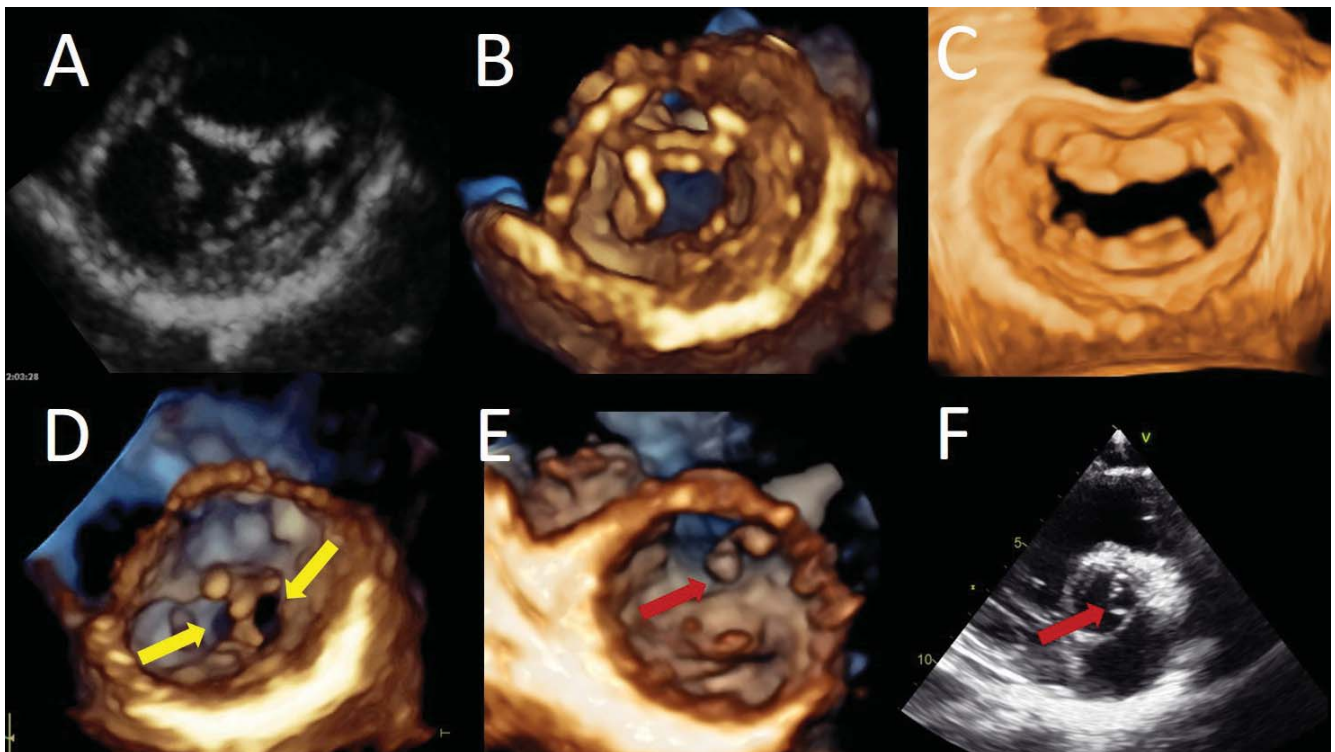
Congenital mitral valve diseases. Two-dimensional short axis view (Panel A) and three-dimensional transthoracic volume rendering of an anterior mitral leaflet cleft from the ventricular perspective (Panel B) in a patient with an incomplete atrio-ventricular canal. Surgical view of the mitral valve showing posterior mitral leaflet cleft, between P2 and P3 scallops (Panel C). Three-dimensional transthoracic volume rendering from the ventricular side showing a double orifice mitral valve - yellow arrows - (Panel D). Transthoracic three-dimensional volume rendering from the ventricular view (Panel E) allowing an accurate identification of the anatomy and localisation of the accessory tissue (red arrow). Two-dimensional transversal cut plane obtained from a transthoracic three-dimensional data set using an intermediary plane between the levels of the aortic valve and the mitral valve to visualise accessory mitral valve tissue (Panel F).
